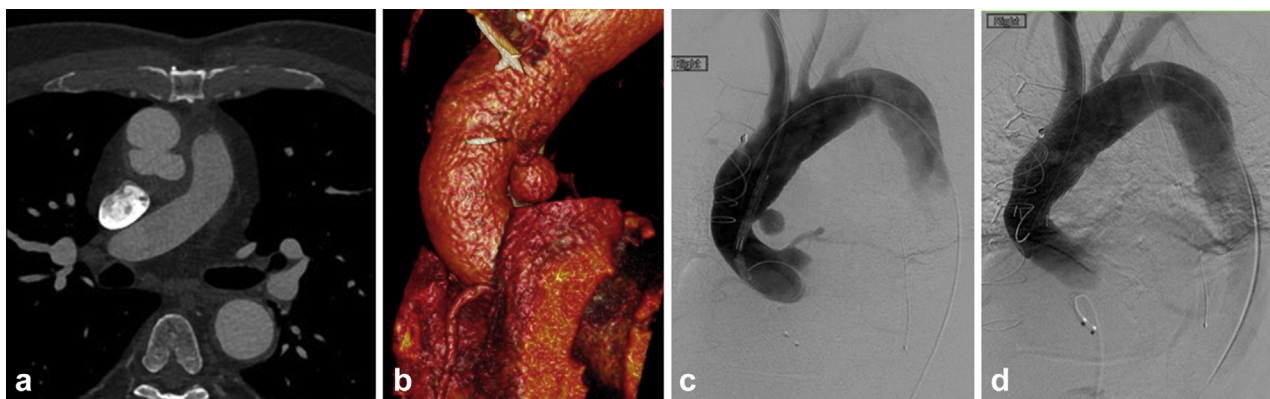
Endovascular treatment approach using a modified stent graft in patient 5. (a) Pretreatment contrast-enhanced CT shows an AAP arising from the posterior aspect of the aortic root (arrow). (b) Volume-rendered reconstruction confirms the posterior position of the AAP. (c) Access to the right axillary artery was achieved by cutdown with the assistance of cardiothoracic surgery due to the exaggerated angle of the aortic arch. digital subtraction angiography (DSA) shows the stent graft delivery device passing into the ascending aorta through the right brachiocephalic artery. The under-used modified stent graft (broad arrow) is positioned across the AAP (arrow). (d) DSA after deployment of the modified stent graft (broad arrow) demonstrates complete exclusion of the AAP. Follow-up contrast-enhanced CT 10 months after treatment shows complete thrombosis of the excluded AAP (not shown).
